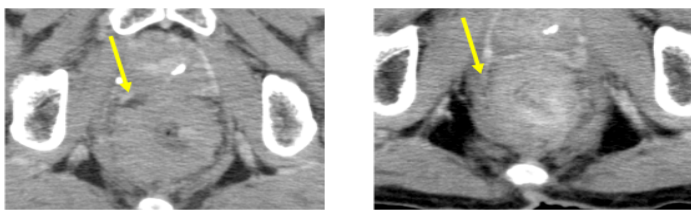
The image of CT before preoperative chemo-radiotherapy (left). The carcinoma invasion to the prostate and packed in pelvis was shown. The image of CT after preoperative chemo-radiotherapy (right). The invasion of carcinoma to prostate was unclear and the size of carcinoma was smaller than before.
